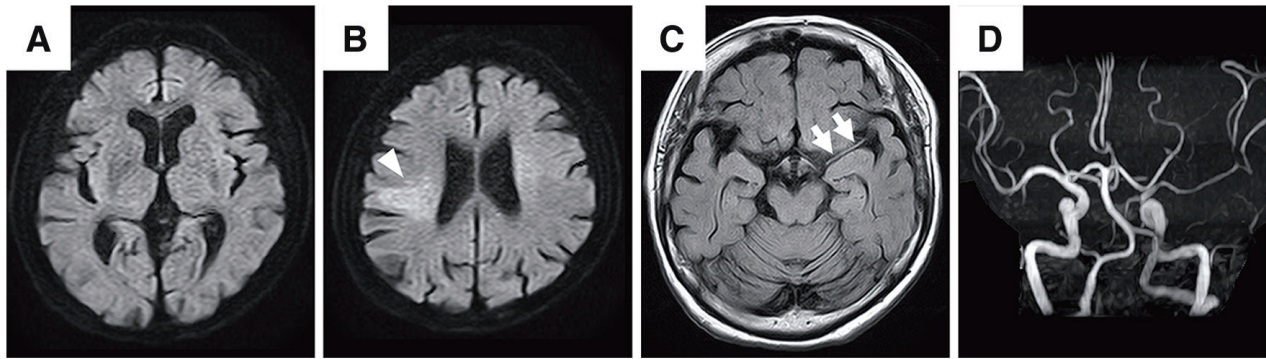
MRI on admission. (A and B) DWI shows no acute infarct in the left MCA territory; hyperacute infarction is visualized in the subcortical right parietal lobe (white arrowhead). (C) FLAIR imaging reveals a vascular hyperintensity in the left proximal Sylvian fissure that courses parallel to the visible MCA trunk (white arrows). (D) MRA
